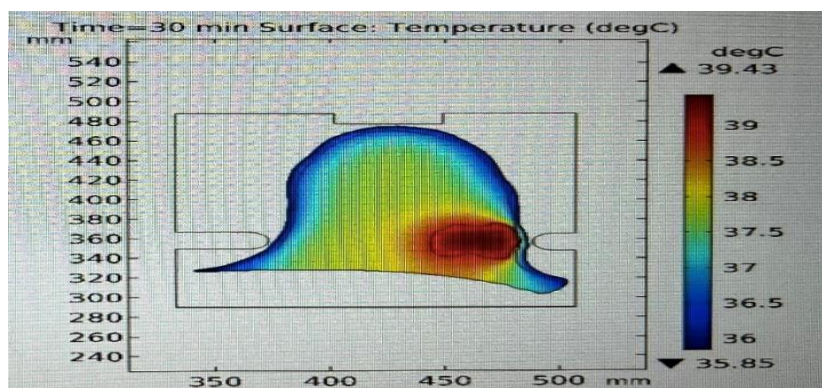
Distribution of SAR calculated from the electric field (A), SAR calculated from the magnetic field (B), and temperature contour (C) in the prime tumor based on a computed tomography axial scan (axes in mm) for MagniTherm utilized with an output power of 75 W. 1 - indicates breast tissue; 2 - prime tumor
